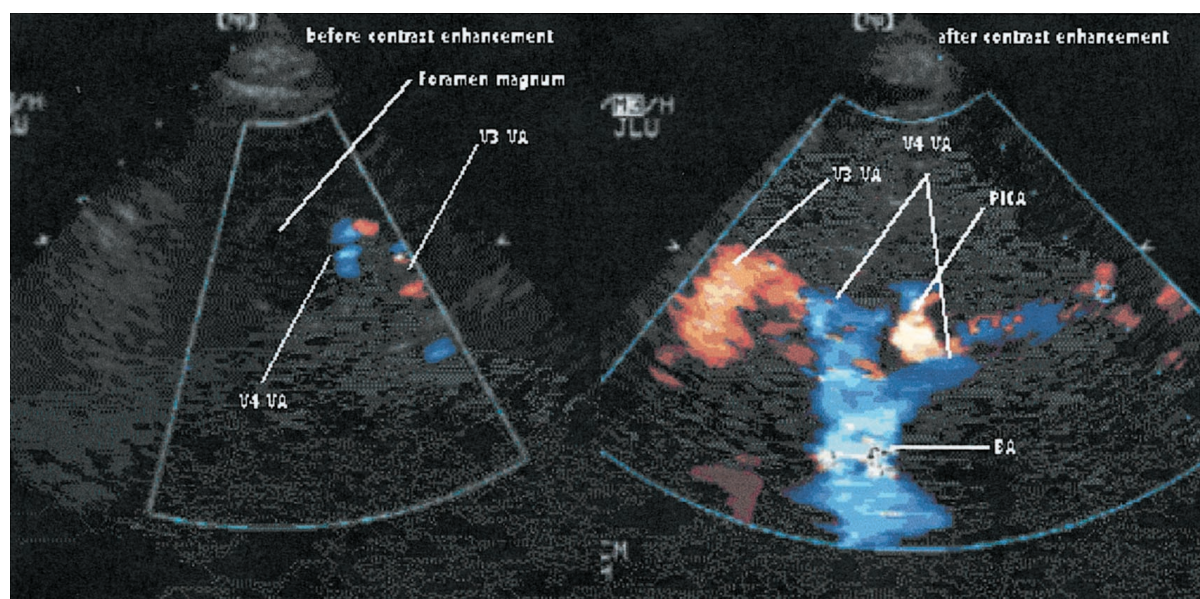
Transforaminal transcranial color-coded duplex sonograms before (left) and after (right) application of an echo-enhancing agent. VA indicates vertebral artery; BA, basilar artery; PICA, posterior inferior cerebellar artery. Before echo enhancement, an occlusion of the intraforaminal part of the vertebral artery might have been falsely assumed.
